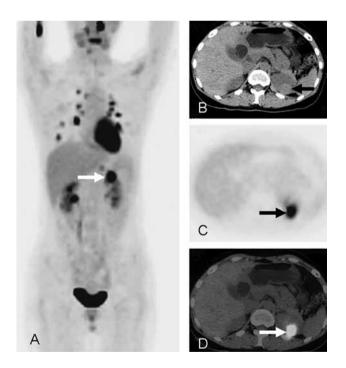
A 74-year-old male patient with lower back pain was given ¹³¹I treatment after total thyroidectomy. No abnormal ¹³¹I uptake was found in the post-therapeutic ¹³¹I-WBS with elevated serum Tg and ¹⁸F-FDG-PET/ CT was performed to search for potential metastatic lesions. Maximum intensity projections in ¹⁸FDG-PET revealed more intense ¹⁸FDG uptake lesions in the chest and abdomen (A: arrow). ¹⁸F-FDG-PET/CT revealed a prominent ¹⁸FDG uptake lesion with a diameter of 23 mm in the upper pole of the left kidney (B-D: arrow).
